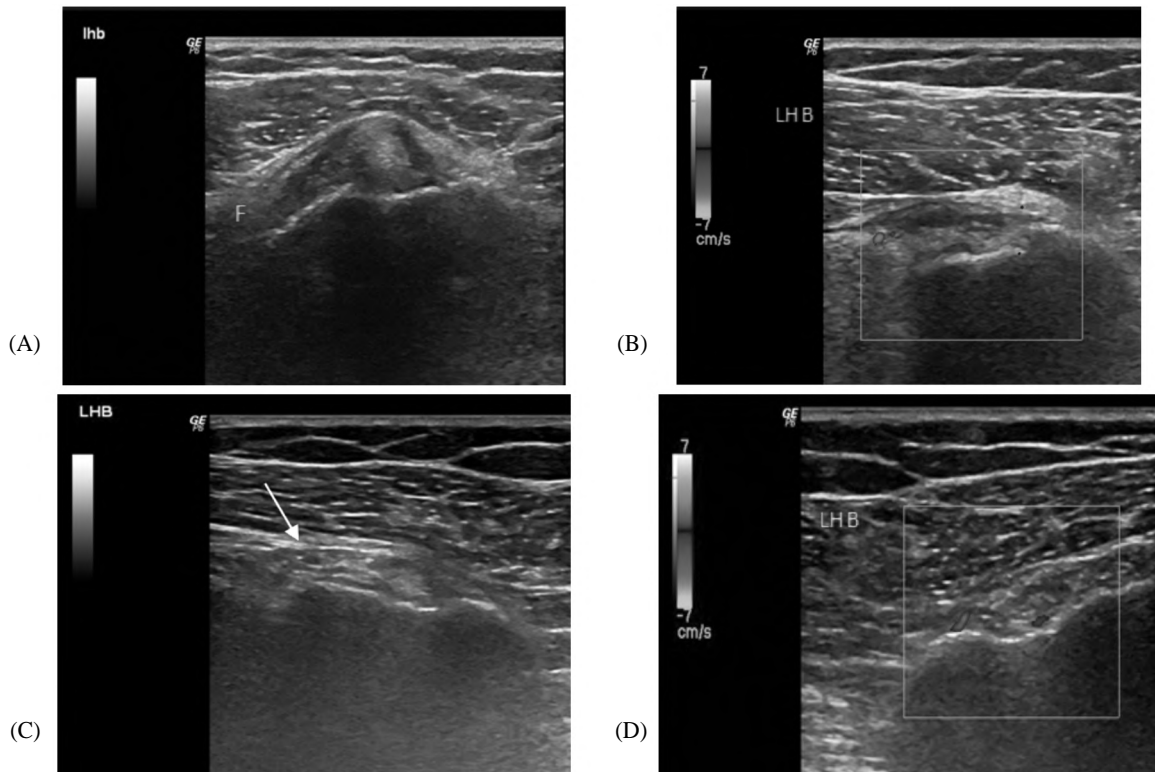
Static (A) and Colour Doppler ultrasonography TS view (B) showed: Evidence of long head of biceps (LHB) tenosynovitis with relative synovial fluid (F) and increased vascularity. Follow-up static (C) and Colour Doppler ultrasonography TS view (D) showed: Decreased amount of long head of biceps (LHB) synovial fluid denoting improvement.
